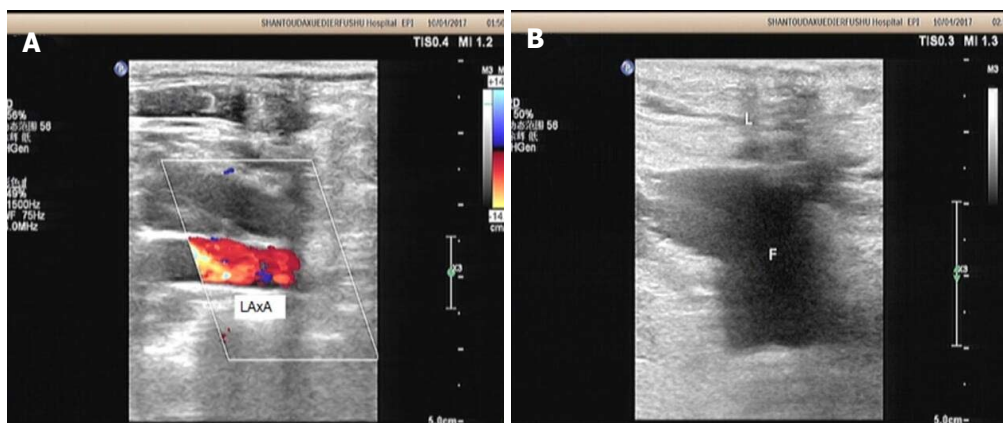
Doppler ultrasound revealed interruption of blood flow through the axillary artery. A: The distal axillary artery was not unclear; B: The perivascular blood accumulation was obvious.
